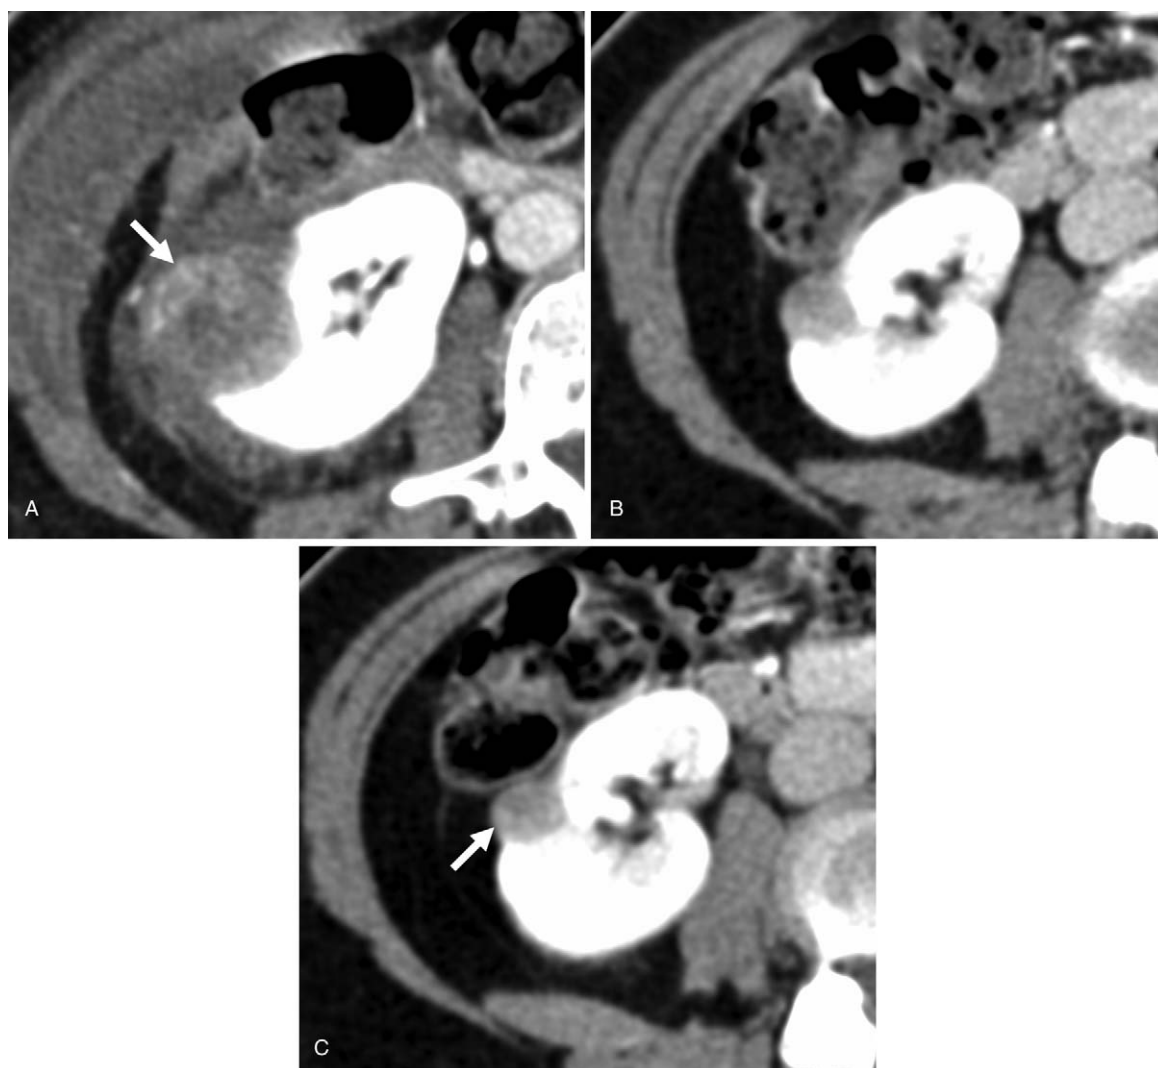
Sequential follow up computed tomographic (CT) images of a middle-aged woman with recurrent metanephric adenoma after cryoablation. (A) Post-contrast CT on the first day after cryoablation. It shows faint enhancement (arrow) in the ablated lesion, indicating hyperemic change or viable tumor. Perirenal hematoma is also noted. (B) and (C) CT scan at 4th and 5th year after thermal ablation. Gradually increased solid component of the lesion as well as mild irregular, nodular enhancement at periphery of the tumor (arrow) can be observed after comparison of sequential follow up images. Recurrence of metanephric adenoma is highly suspected.
